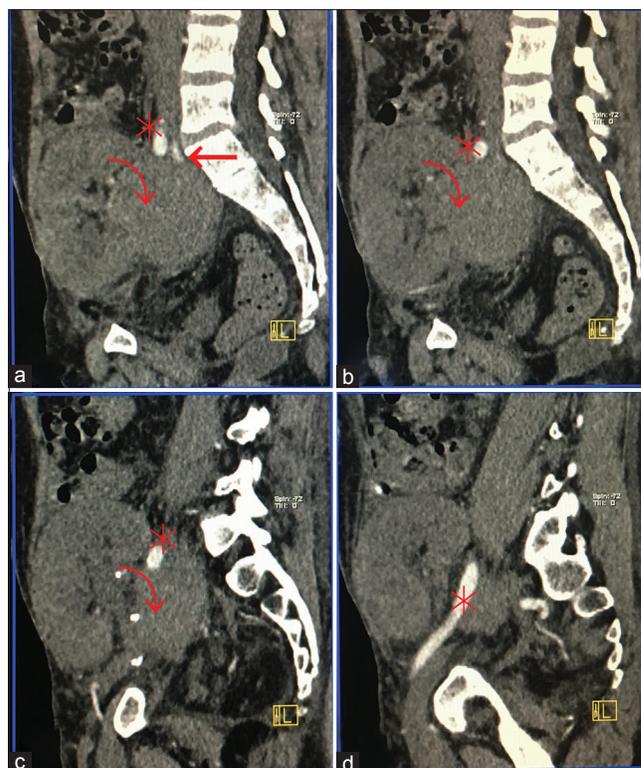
Computed tomography angiographic images showing large mildly enhancing thrombosed pseudoaneurysm (Curved arrow-[a and b]) at the junction with graft renal artery (oblique leftward arrow-[a]), native contracted kidneys (c), and displacement of the right common iliac vein (d)
